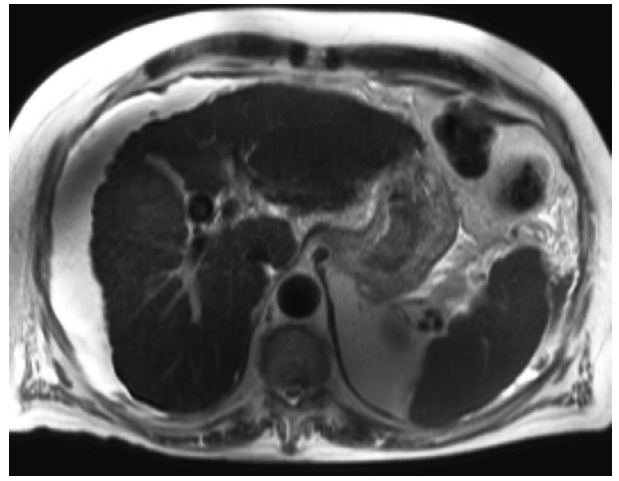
Liver. MRI. T2 weighted. Single shot. Axial plane.
